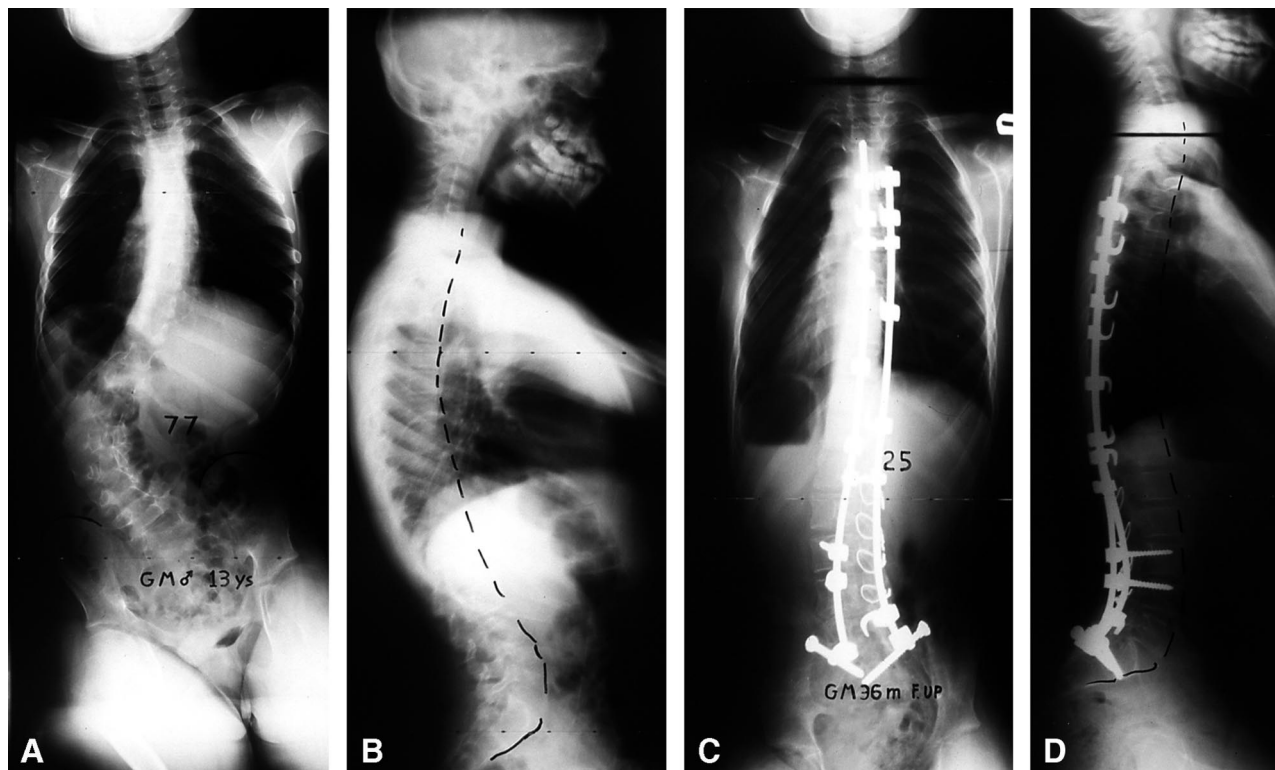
A and B, Posteroanterior and lateral preoperative radiographs of a 13-year-old male patient with spastic quadriplegia treated in 1998. C and D, Posteroanterior and lateral radiographs 3 years following posterior spino-pelvic fusion with tibial autograft.
